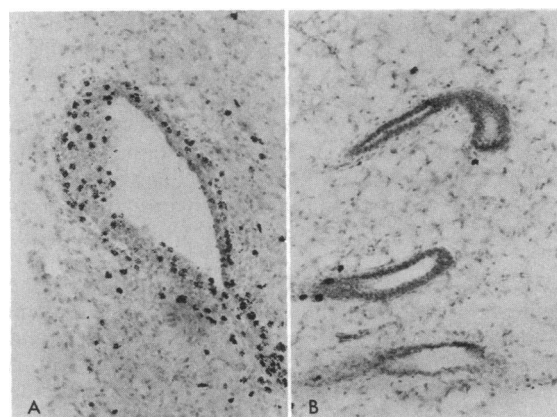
DNA autoradiographs from untreated and CT-treated glands. (A) End bud in the vicinity of a CT implant in the gland pictured in Fig. 1A. Extensive labeling is seen in the epithelium, with some labeling also visible in the stroma. ($\times 180$.) (B) Gland contralateral to that pictured in A. The lack of epithelial labeling and the small size of the regressed ducts are apparent. ($\times 180$.)
